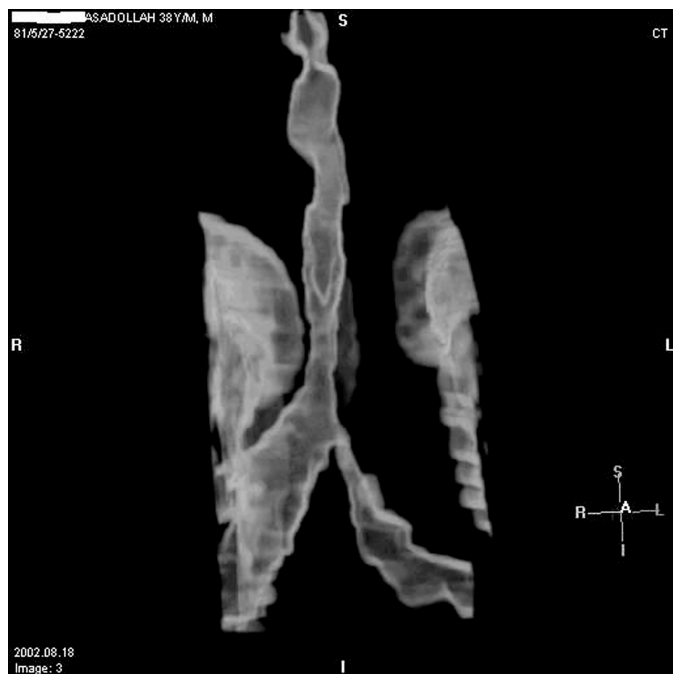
Three-dimensional reconstruction of thoracic CT scan showing severe total tracheal and left main bronchial stenosis in 38-yr-old man.
